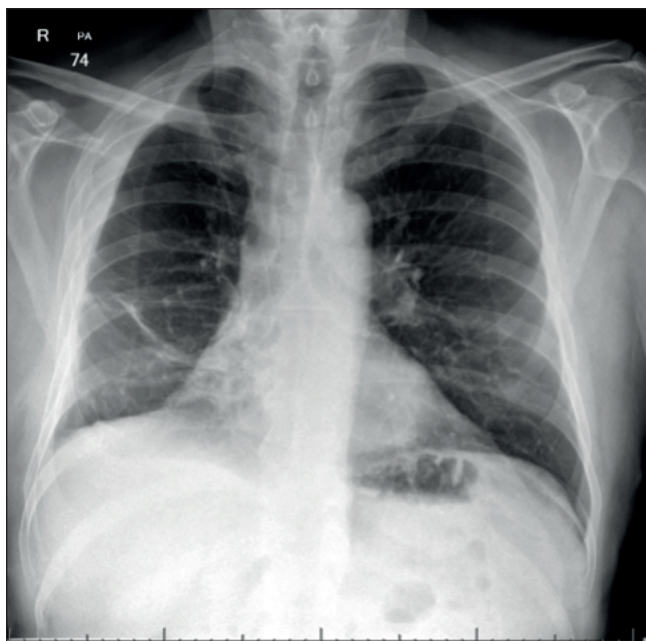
Chest X-Ray 20 days post-procedure, showing extensive resolution of changes
